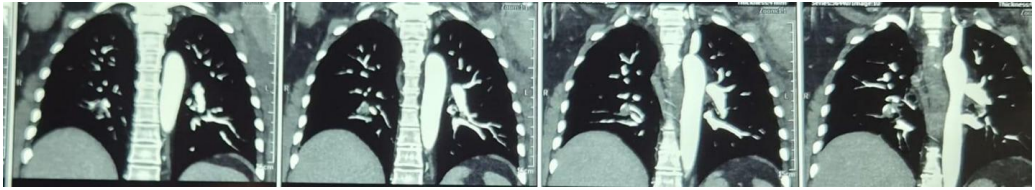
Coronal CT Pulmonary Angiography (C-CTPA),demonstrating contrast-filled pulmonary arteries with central filling defects (dark intraluminal areas), classic for pulmonary emboli in both lungs.
